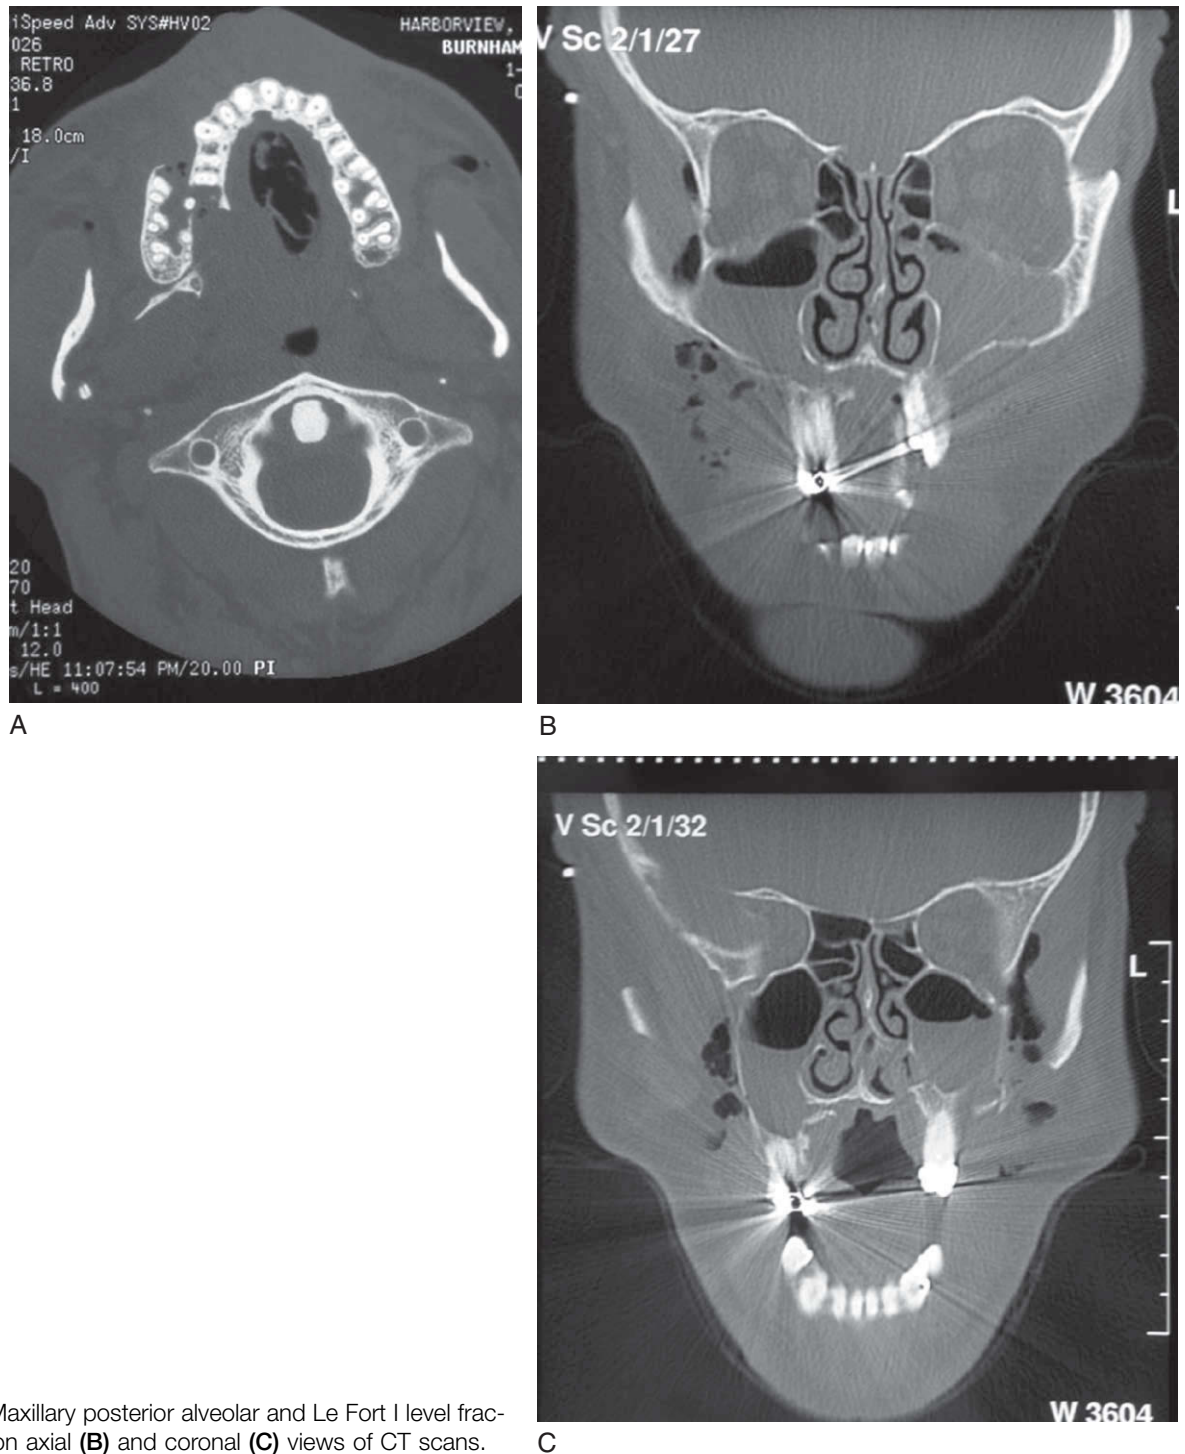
A, Maxillary posterior alveolar and Le Fort I level fractures detected on axial (B) and coronal (C) views of CT scans.
